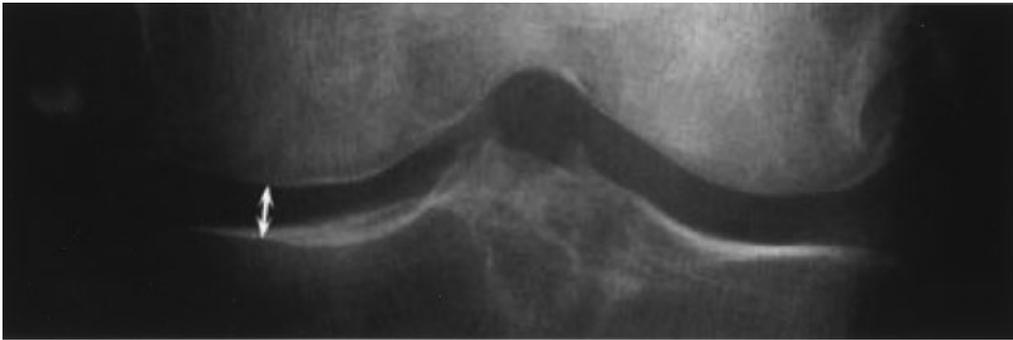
Radiographic image of the tibiofemoral joint space. Double-headed arrow indicates the minimum joint space width in the medial compartment, measured between the distal margin of the femur and the “floor” of the joint space, i.e., the dense cortical line representing the medial tibial plateau. To achieve reproducible radioanatomic alignment of the medial tibial plateau in serial examinations, fluoroscopy can be used to adjust the degree of knee flexion relative to the angle of the x-ray beam. Alternatively, the degree of knee flexion may be fixed and the angle of the beam adjusted to achieve alignment.
